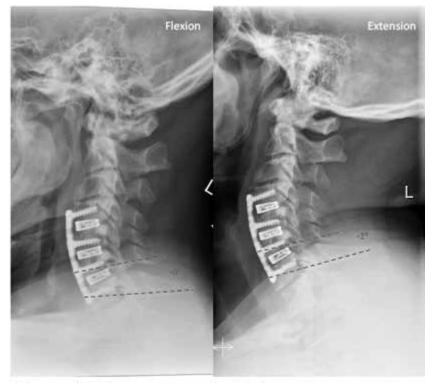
Measurement of interspinous motion on dynamic radiographs using angles between spinous processes
